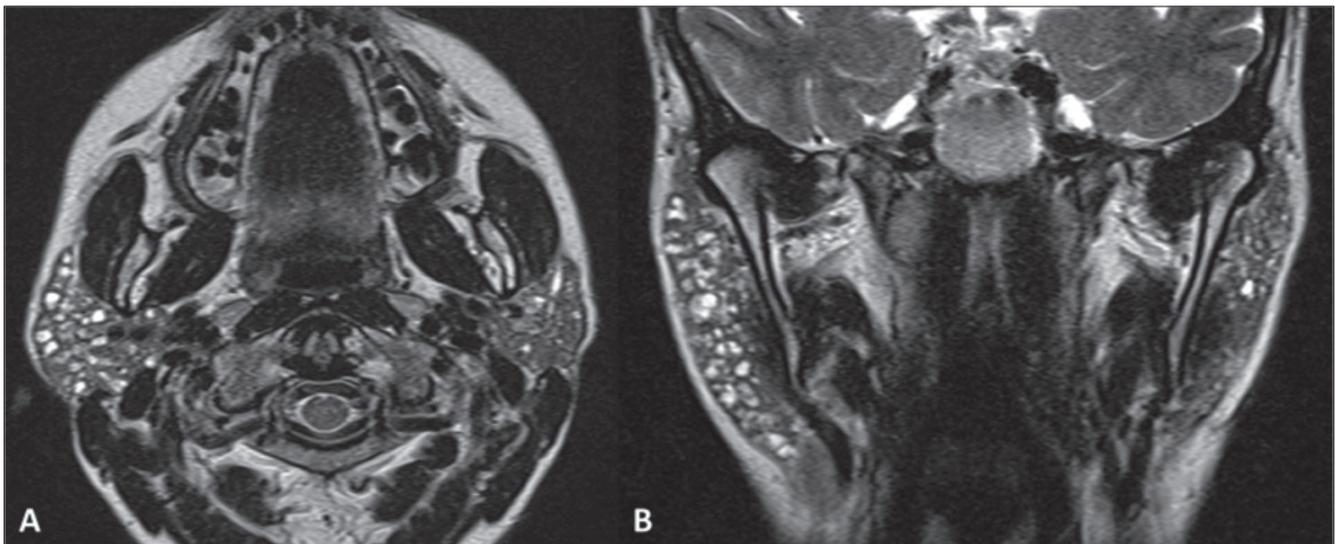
Sjögren's syndrome – intermediate disease. MR TSE T2-weighted sequences on the axial (A) and coronal (B) planes. Bilateral parotid tiny ductal dilatation, particularly evident on the right.
